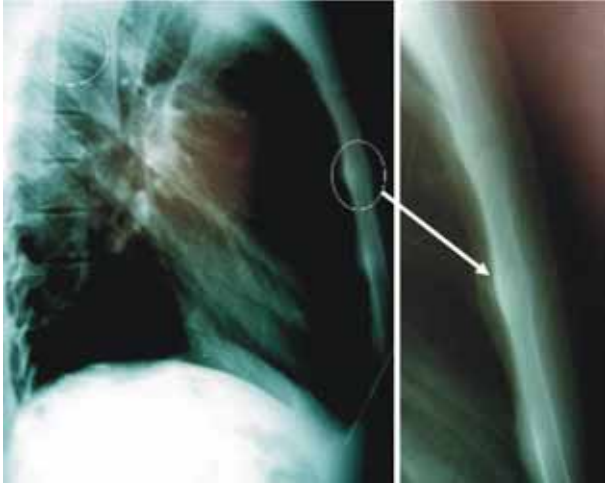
Sternal radiography: a non-displaced *ü*corpus sternal fracture line and also a wedge fracture of 5 vertebrae.
